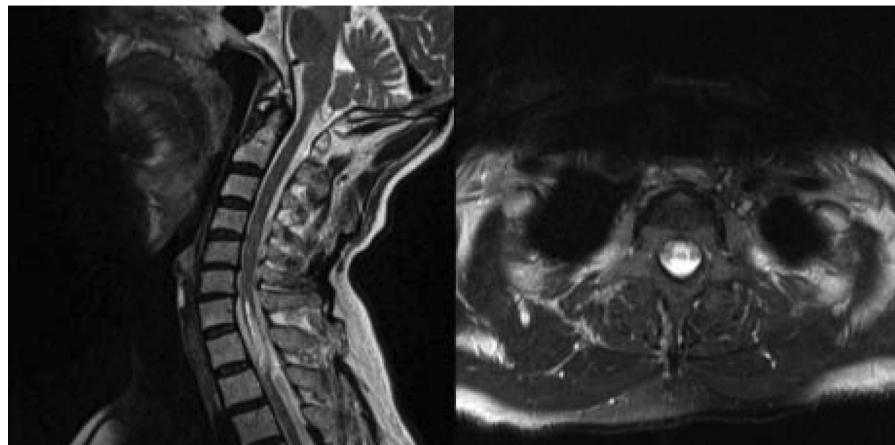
Magnetic resonance imaging (MRI) of cervical spine. (Left) Sagittal T2-weighted MRI that reveals a syrinx from the C6–C7 level to the T2 level. (Right) Axial T2-weighted MRI that reveals ventral migration of the spinal cord with intramedullary T2 signal change.
